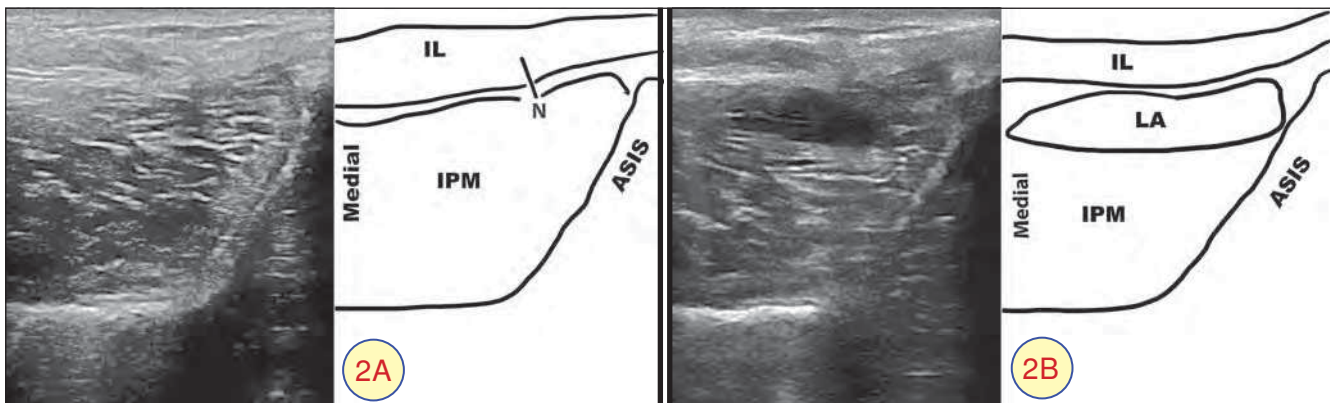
Ultrasound guided block of the lateral femoral cutaneous nerve.
